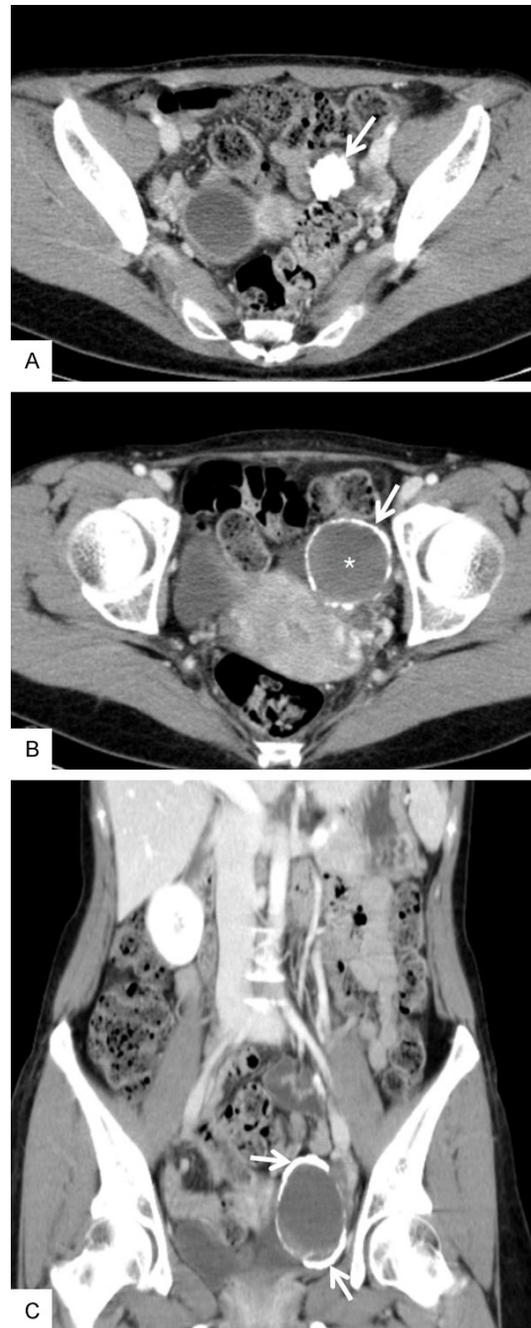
Computed tomographic findings of ossification of the ovary. Axial (A, B) and coronal-reformatted (C) contrast-enhanced CT images showing a well-defined cystic lesion with internal hemorrhage (*) and peripheral curvilinear calcifications (arrows) in the left ovary. A functional cyst was noted in the right ovary.
